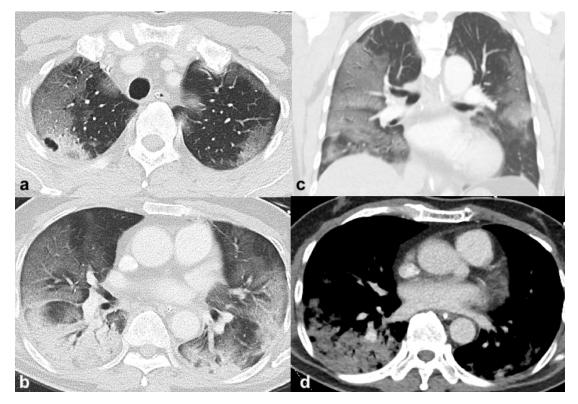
Axial images showed lung and soft tissue reconstruction and coronal image revealed lung reconstruction. Contrast-enhanced chest computed tomography showed ground-glass opacities predominantly in the upper lobes, with stark thin rim of subpleural sparing. Mild smooth intralobular septal thickening giving the appearance of "crazy paving" was observed. Consolidation was present in the dependent segments of both lungs with an asymmetric distribution, predominantly involving the right lower lobe. An incidental small thin-walled subpleural cyst in the right upper lobe likely represents a pneumatocele. Neither intrathoracic lymphadenopathy nor pleural effusion was observed.
